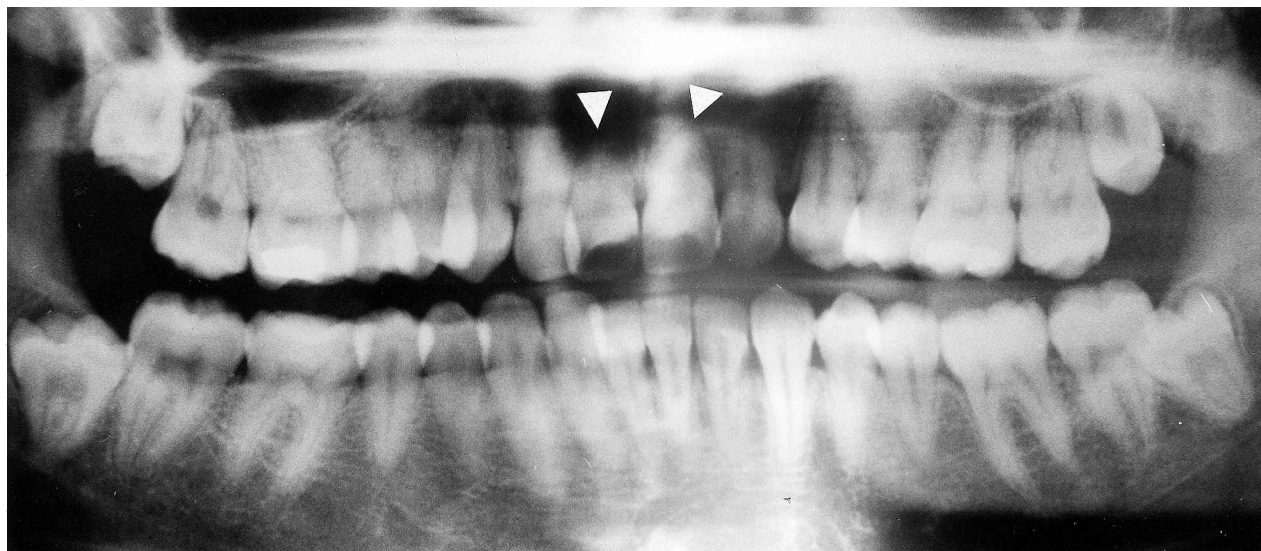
Panoramic radiograph of a 24-year-old female student with short-root anomaly. Maxillary central incisors are strongly affected with round apices (arrowheads). Short roots are seen throughout the dentition. No orthodontic treatment has been done.
